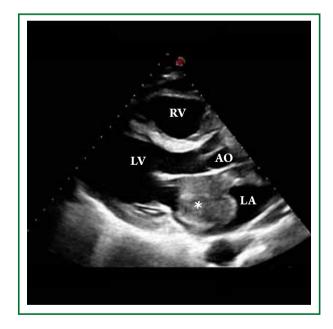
Two-dimensional echocardiographic parasternal long axis view showing a large solid mass (*) almost obstructing the left atrium.
